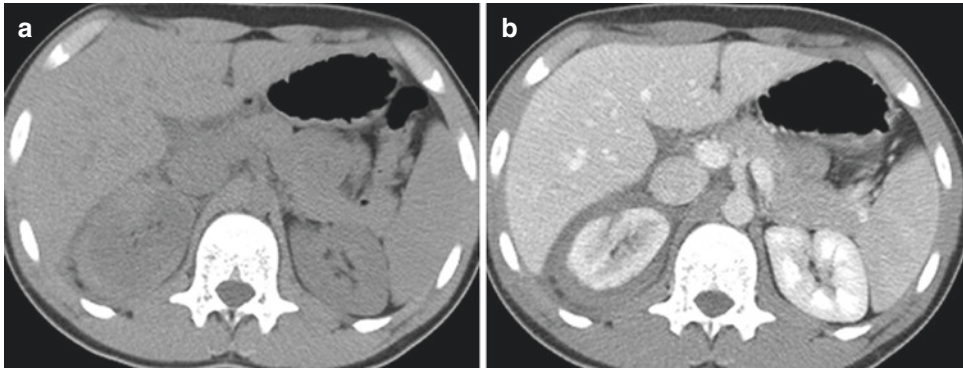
CT (a, b) confirms right renal parenchymal lesion with peri-renal fluid collection
